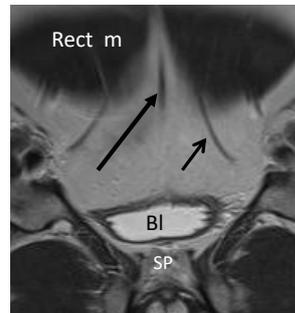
Coronal T2-w TSE MR image taken behind the symphysis pubis (SP), at the level of the rectum abdominis muscle (Rect m) showing the median (long arrow) and the lateral umbilico vesical ligaments (short arrow).
